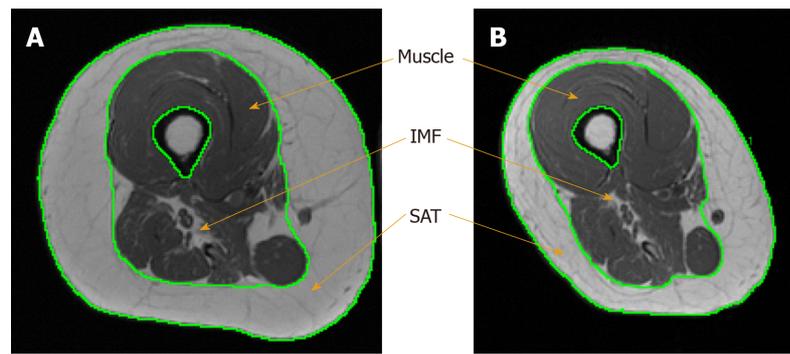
Robust changes in subcutaneous adipose tissue, intramuscular fat and muscle size between baseline and post-intervention measurements. A: Baseline magnetic resonance imaging (MRI) of the right thigh showing large subcutaneous adipose tissue (SAT) and intramuscular fat (IMF) depots prior to dietary intervention; B: Post-intervention matched MRI of right thigh after 16 wk of intervention showing reduced SAT and IMF depots and increased muscle cross-sectional area.
